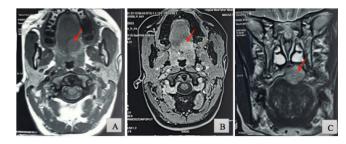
Facial MRI showing a left well-limited two-centimeter soft palate tumor with low signal T1 (A), intermediate signal T1 FAT SAT gadolinium-enhanced (B) and T2 moderate enhancement (C) (red arrows).
